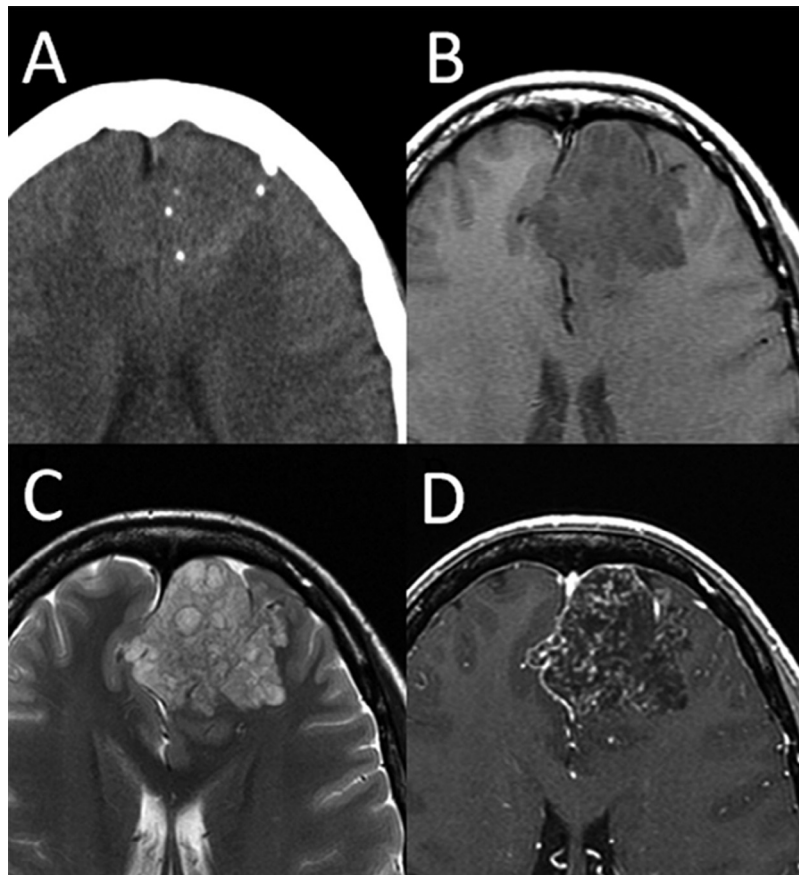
Demonstration of conventional imaging. (A) Plain CT; (B) T1WI; (C) T2WI; (D) Gd-T1WI. CT, computed tomography; T1WI, T1-weighted imaging; T2WI, T2-weighted imaging; Gd-T1WI, gadolinium-enhanced T1-weighted imaging.
